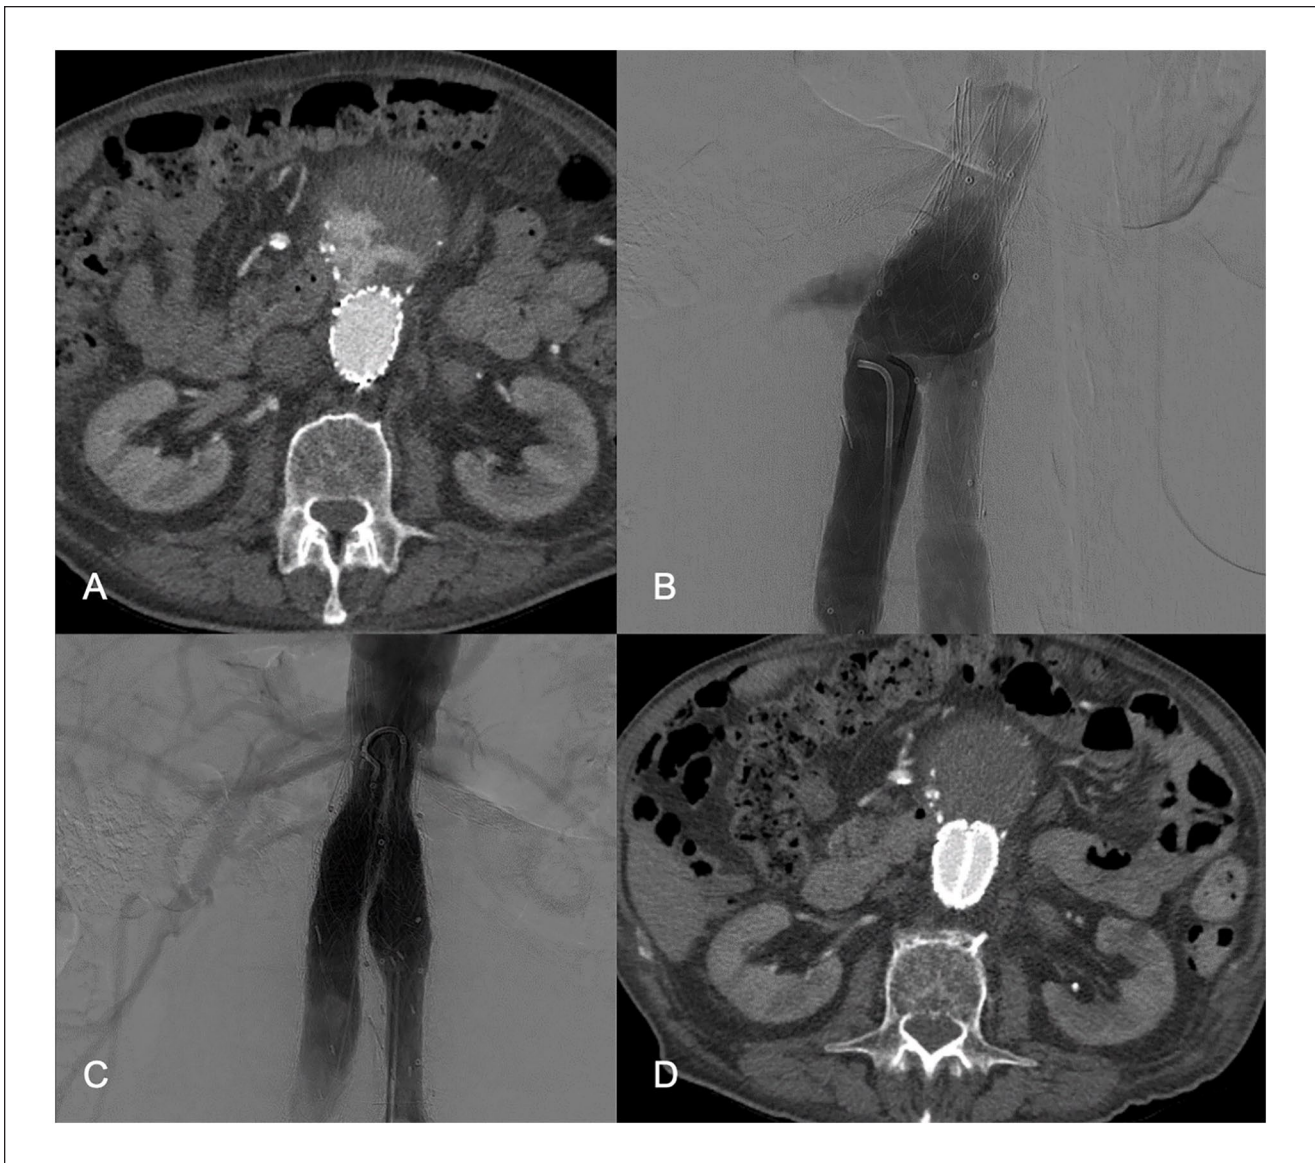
(A) Computed tomographic (CT) scan showing a type III endoleak at the level of the flow divider. (B) Angiography confirming a type III endoleak. (C) Completion angiography after implanting 2 upside-down Gore Excluder contralateral limbs. (D) Follow-up CT scan showing a double-D configuration and absence of any endoleak.
